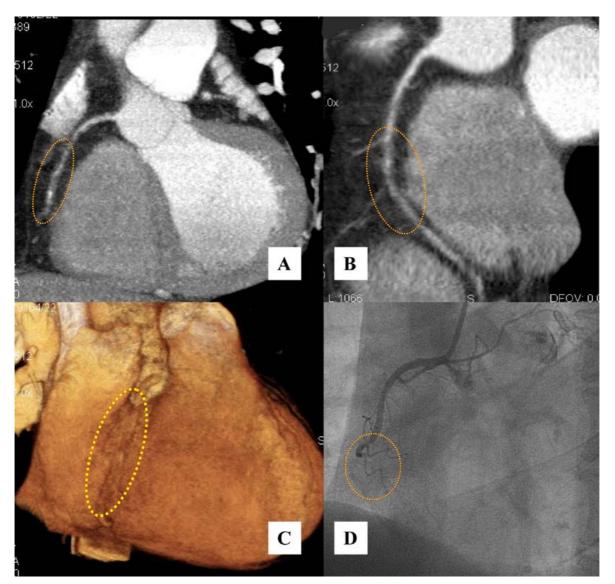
A 49-year-old man was present with dyspnea on exertion. A-C show severe stenosis at the middle segment of the RCA in CT angiogram. D presents complete occlusion at this site by conventional coronary angiogram
